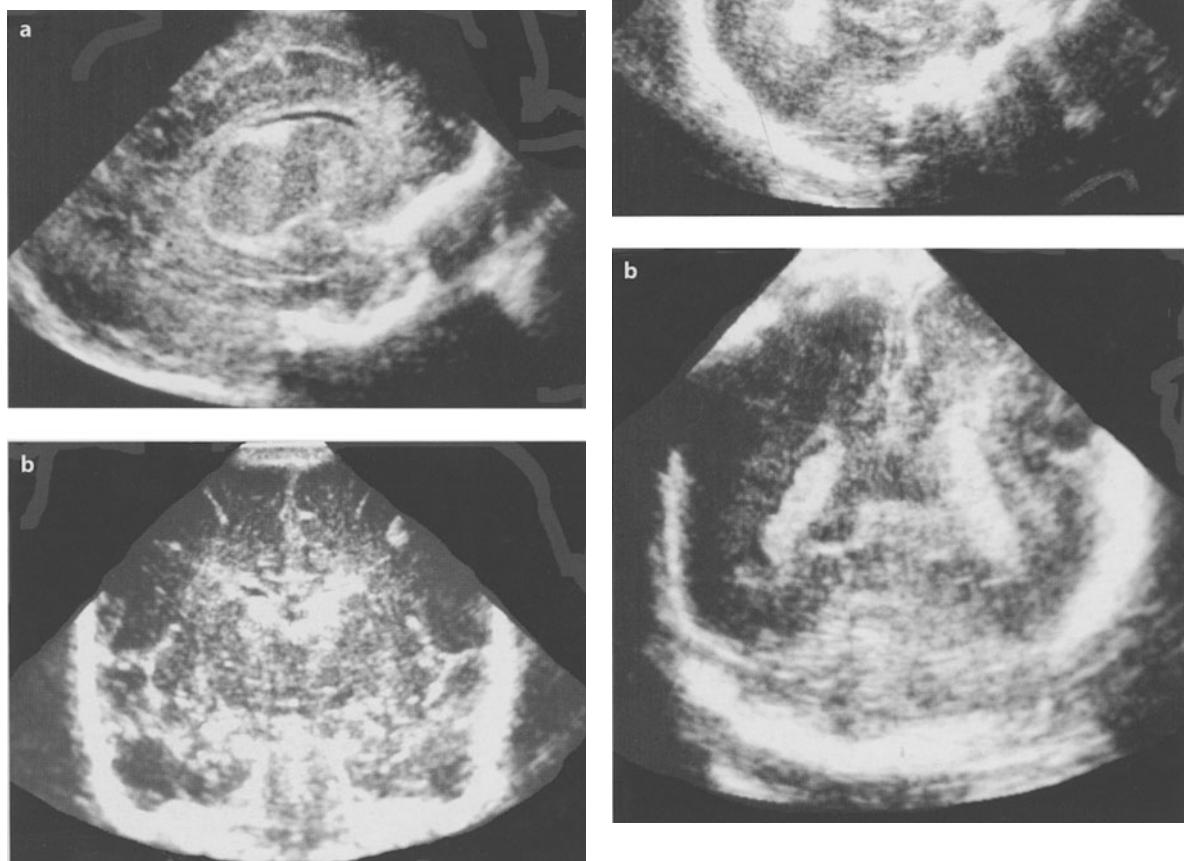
Right sagittal and coronal ultrasound images of a Papile grade I subependymal hemorrhage. Note hyperechoic signal in the region beneath the ventricle
